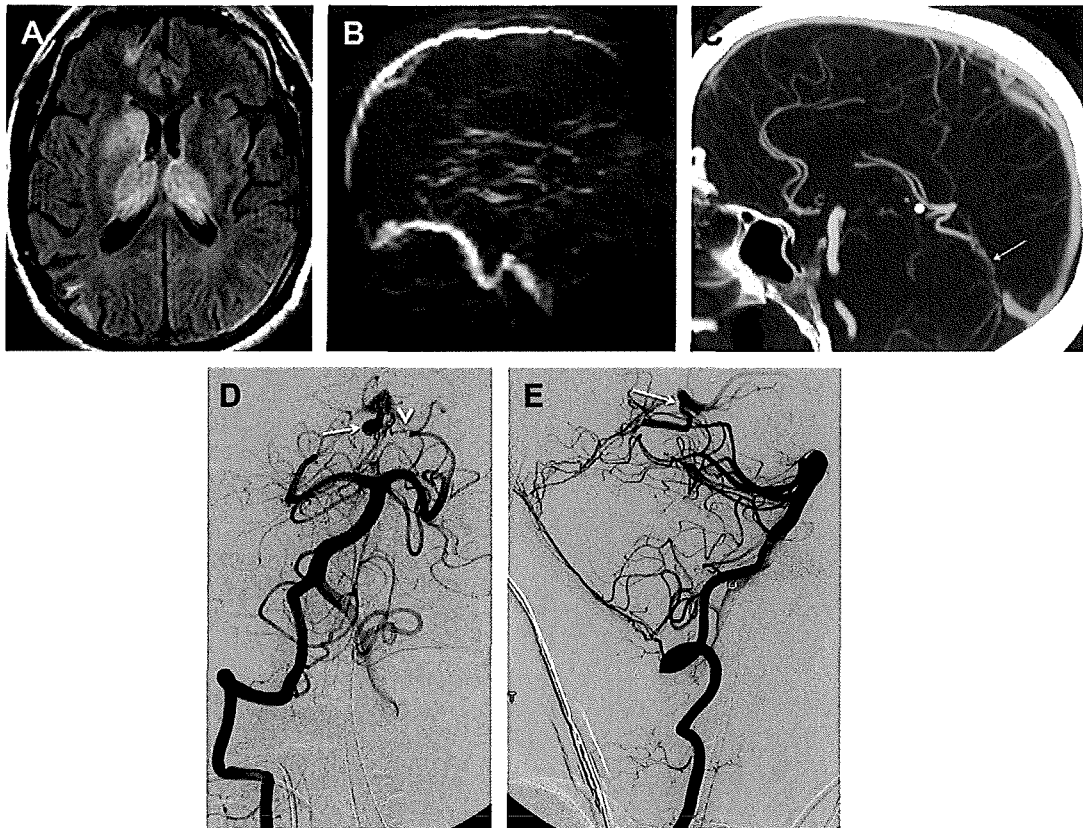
Deep venous thrombosis and dural arteriovenous fistula. Axial FLAIR image (A) shows FLAIR hyperintensity in the right basal ganglia and bilateral thalami. Maximum intensity projection image from 2-dimensional time-of-flight MR venography (B) demonstrates lack of flow-related enhancement in the straight sinus consistent with dural sinus thrombosis. On the sagittal CT angiographic image (C), there is no visualization of most of the straight sinus (arrow), compatible with thrombosis. Anteroposterior and lateral catheter angiograms with right vertebral injection (D, E) show a dural arteriovenous fistula within the straight sinus with a left posterior cerebral artery branch arterial feeder (arrowheads) and early filling of deep veins including the vein of Galen (arrows). On more delayed images (not shown), there was nonvisualization of the straight sinus, compatible with dural sinus thrombosis.
